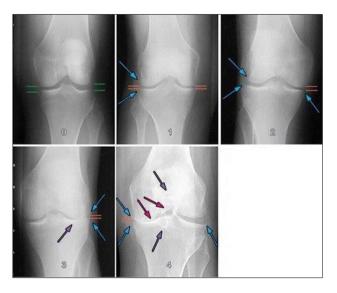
Knee X-Ray Based on Kellgren-Lawrence Scoring System
